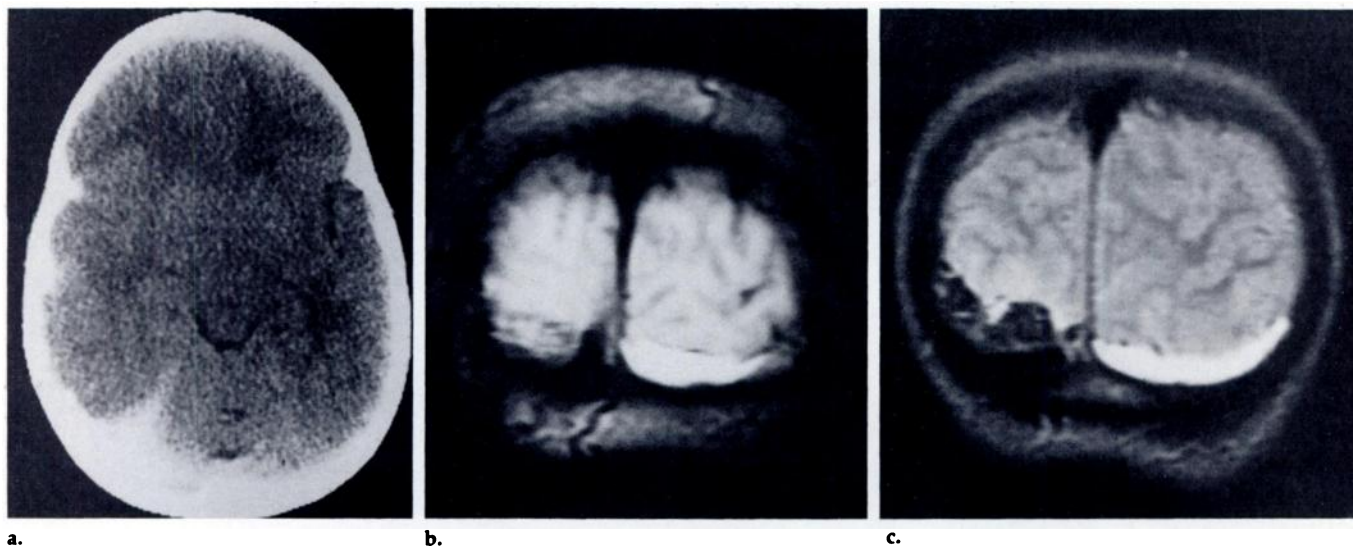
(a) CT scan of 7-year-old hemophiliac with acute right subtemporal and suboccipital SDH (about 1 week old). (b) Coronal T1-WI (TR, 800 msec; TE, 20 msec). The recent right-sided suboccipital SDH is isointense to gray matter. An unsuspected chronic left-sided suboccipital SDH is homogeneously hyperintense. (c) Coronal T2-WI (TR, 2,000 msec; TE, 70 msec). The recent SDH is markedly hypointense, and the chronic SDH remains hyperintense. Note the lack of a hypointense rim around the chronic SDH.
